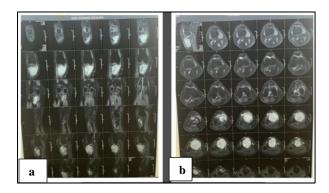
(a and b): Magnetic resonance imaging of tumour.
